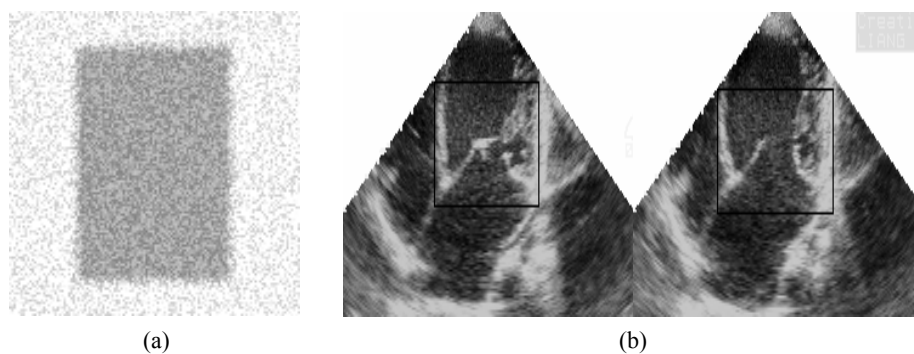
Source images: synthetic images and medical images. (a) Synthetic image; (b) Real ultrasound images
